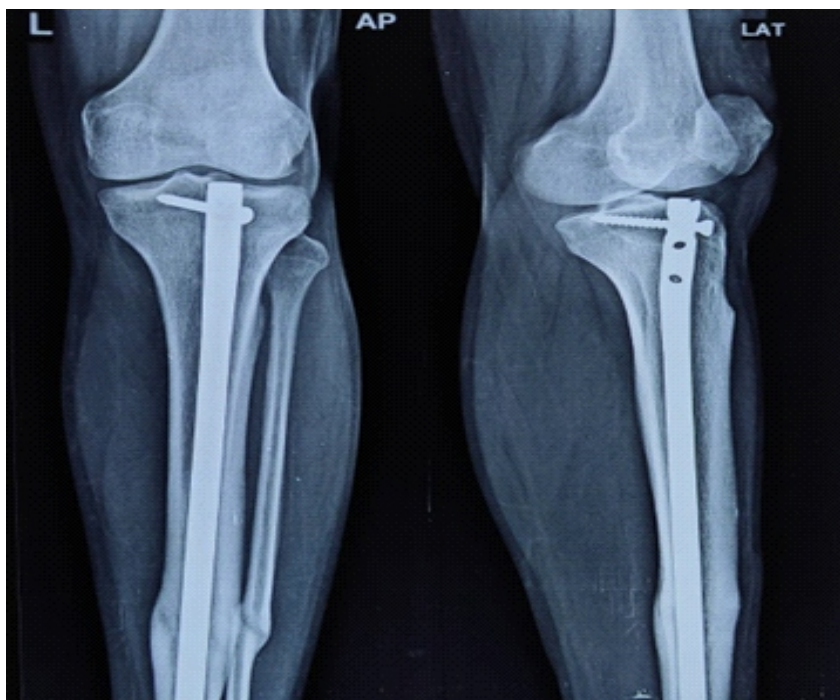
Follow-up radiograph showing satisfactory fracture union.
